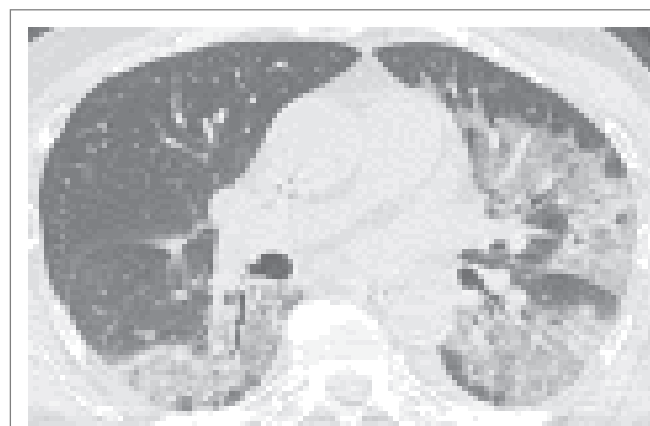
Unenhanced chest CT.
